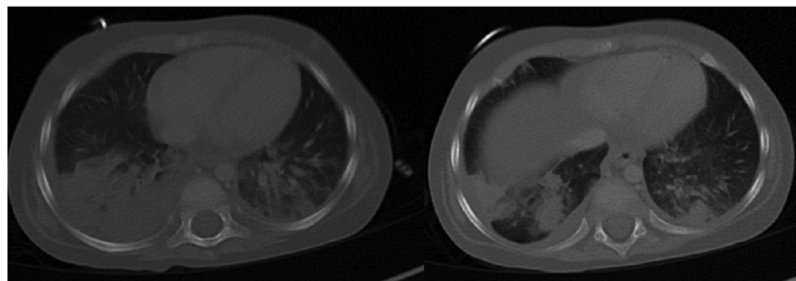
Chest CT-scan on day 38 of induction treatment.
